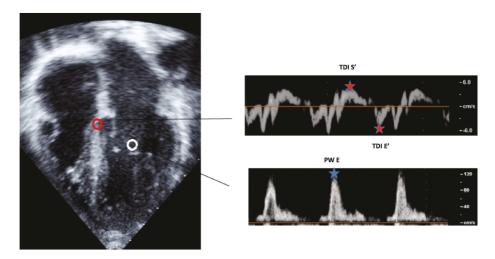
Example of analysis of peak velocities measured by Tissue Doppler Imaging (TDI) in a high-risk neuroblastoma survivor. The peak systolic (TDI S') and diastolic (TDI E') velocities are indicated. The early left ventricular inflow diastolic velocity (PW E) was measured with Pulse Wave Doppler (PW).
